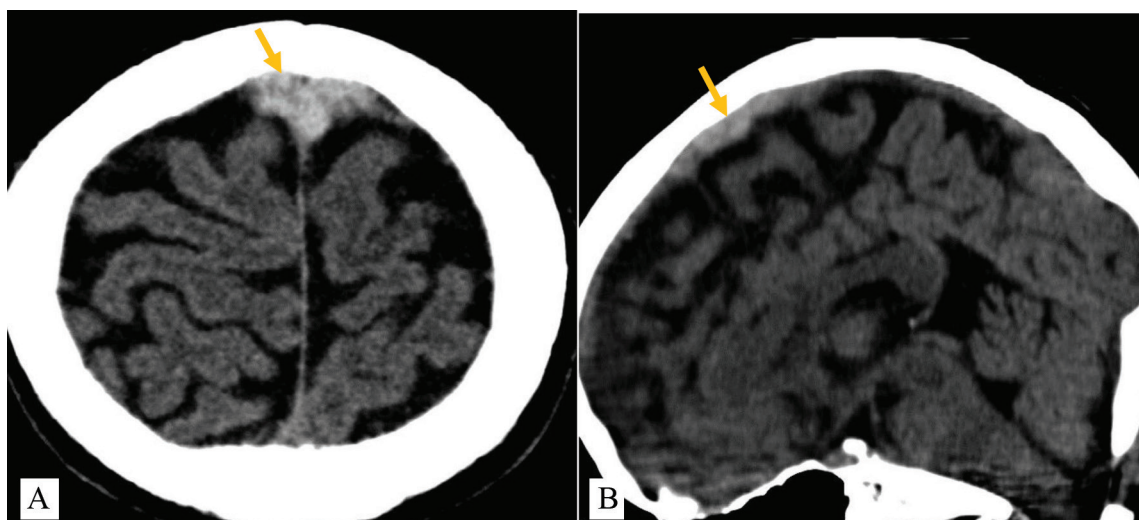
Brain CT scan shows hyperdense and thickened mid part of superior sagittal sinus (arrows) in axial cut (A) and sagittal cut (B).
